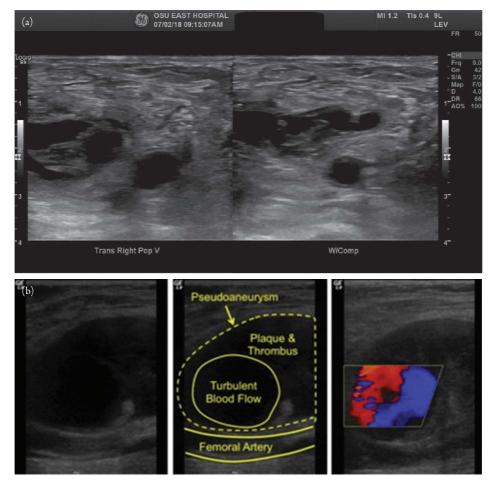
(a) Baker's cyst. (b) Pseudoaneurysm with "to and fro" waveform. Adapted from Figure 20 of Cook T, Nolting L, Barr C, Hunt P. Diagnostic ultrasonography for peripheral vascular emergencies. *Crit Care Clin*. 2014;30(2):185–206.
